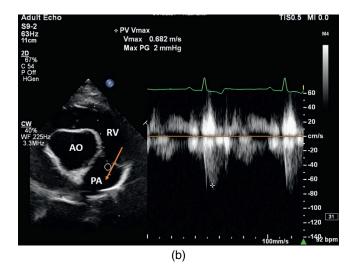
Any deviation from parallel to flow will underestimate the true velocity. (a) Here the actual direction of flow into the aorta is the solid line and the Doppler cursor (dashed line) is not parallel to the flow. Flow velocity will be underestimated. (*Continued*)
